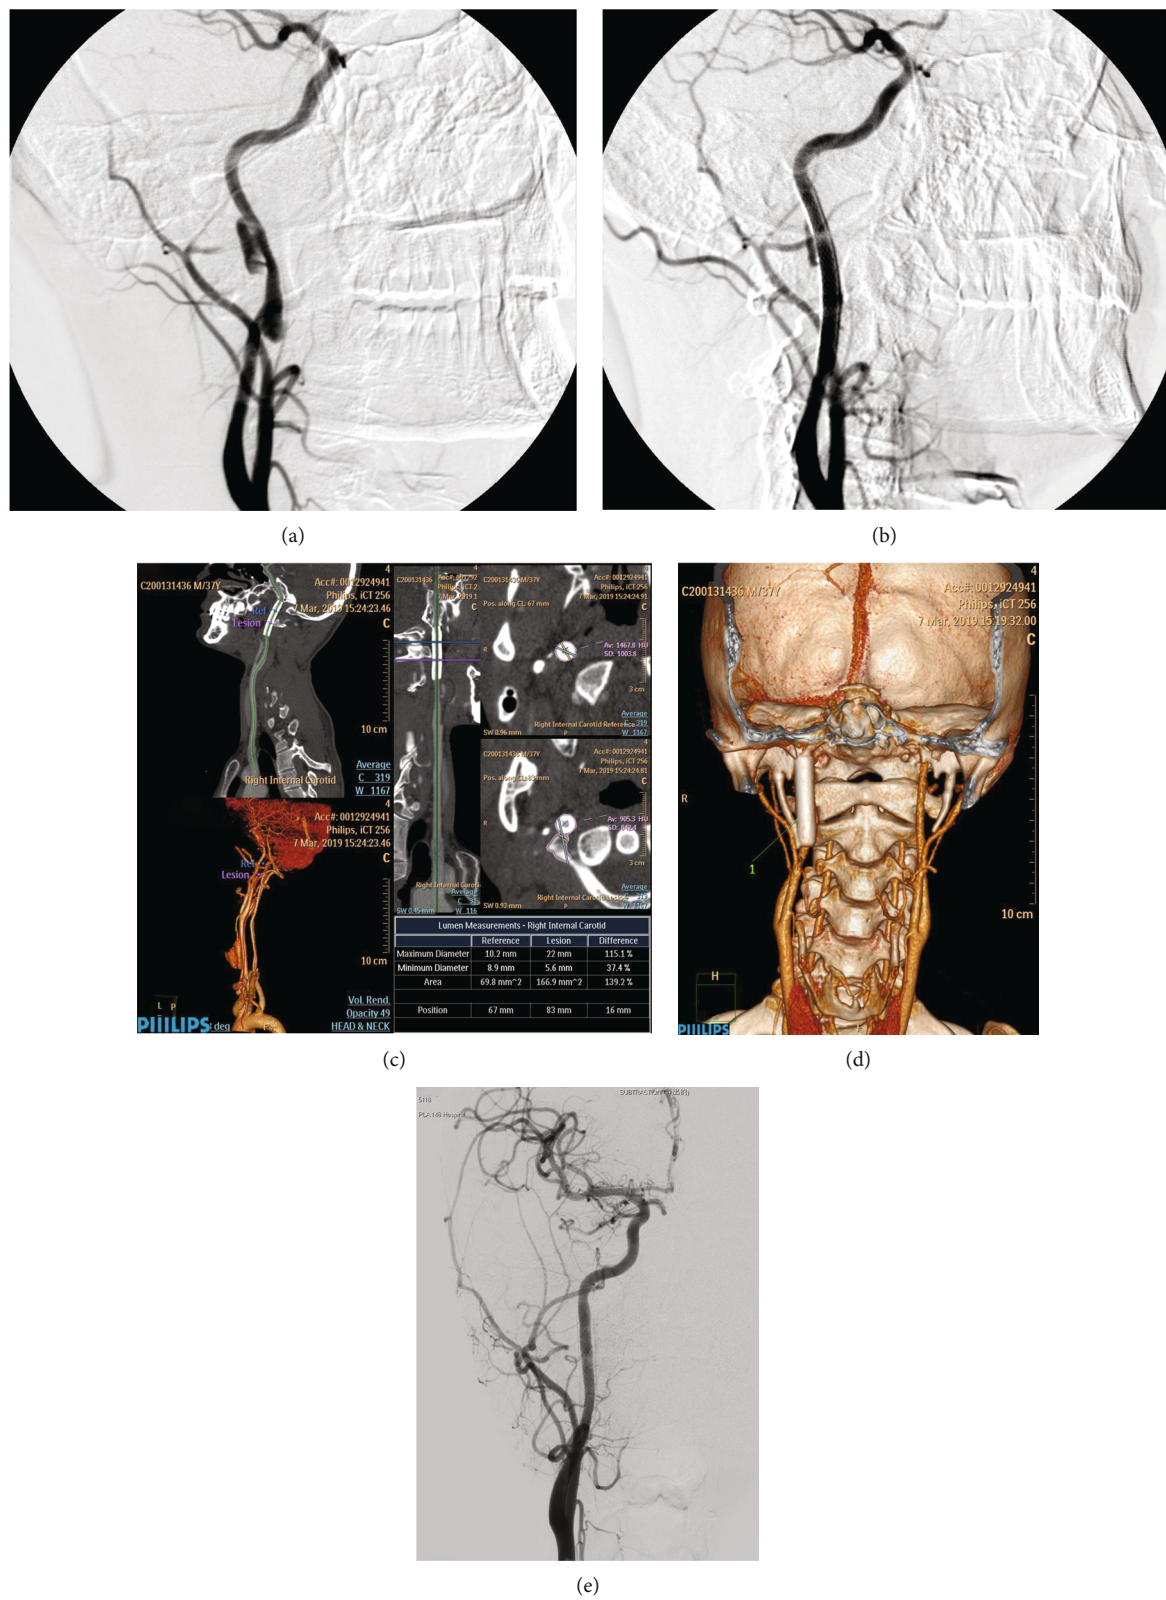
Pseudoaneurysm of the right common carotid artery caused by head trauma. (a) DSA before operation in February 2011 revealed a pseudoaneurysm of the right common carotid artery. (b) After double-layer bare stent placement, DSA showed that the hematoma cavity disappeared and no contrast extravasation. (c, d) CTA in Mar 2019 revealed that the blood flow in the stent lumen was smooth, and there was no stenosis in the lumen. (e) Angiography in May 2019 showed that the blood flow in the stent lumen was smooth, and there was no stenosis in the lumen.
